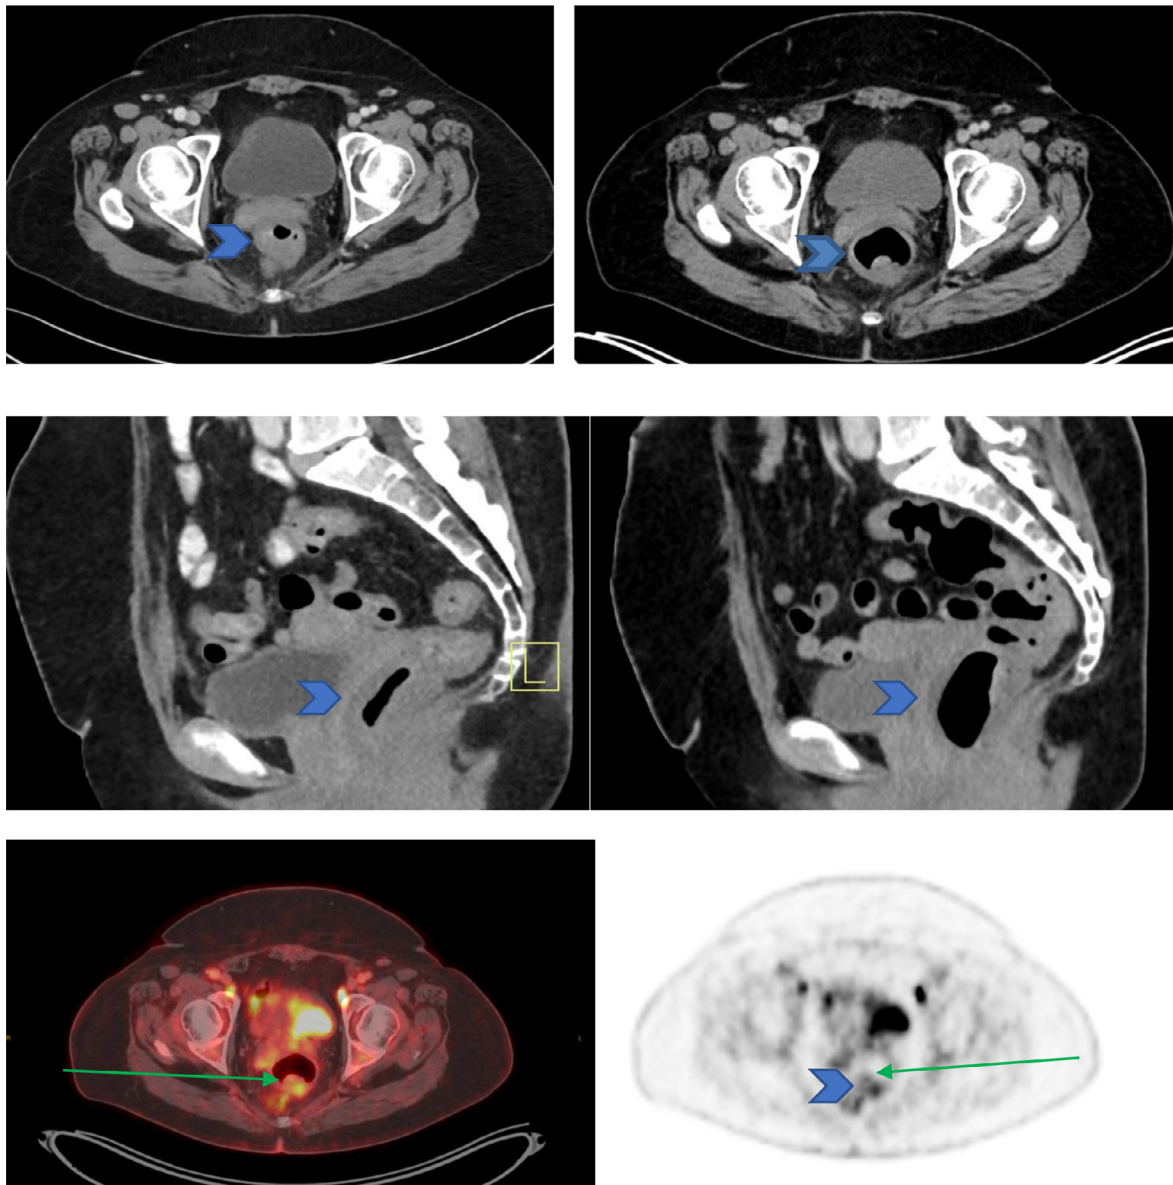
Transverse section CT [upper row] and coronal section [second row] by admission (left) and eight days later as part of PET-CT (right) showing the regression of the rectum wall thickening. Transverse section of fusion image (left) and PET (right) [third row] showing mild focal FDG uptake (SUV max = 5.6) in the residual thickening of the rectum wall. Please note the physiological faecal activity (green arrows). (Color version is available online).
